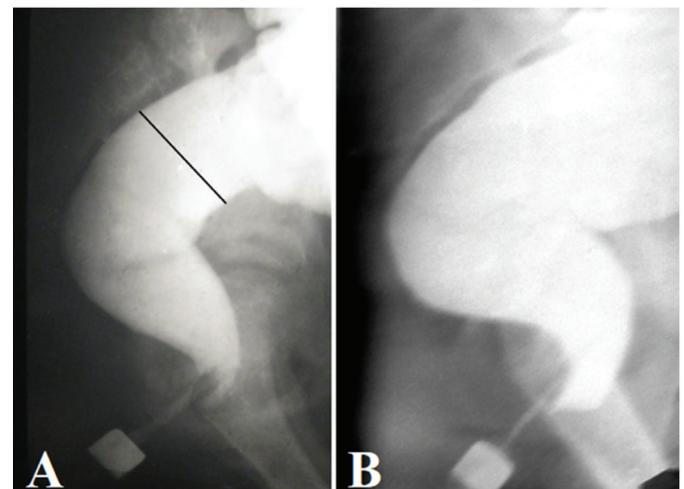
Lateral radiographs of anorectum during a barium enema. (A). The true length of the anal canal is equal to the distance between the rectum and the marker, multiplied by a distortion coefficient equal to the ratio of the true diameter of the marker (1.6 cm) to the width of its image on the radiograph. (B). During the study, barium penetrates periodically into the anal canal in front of the tip of the enema. At this time, the posterior wall of the anal canal is always pressed against the tip by the contracted PRM. After a few seconds, barium disappears from the anal canal. It is squeezed into the rectum because of a contraction of IAS
